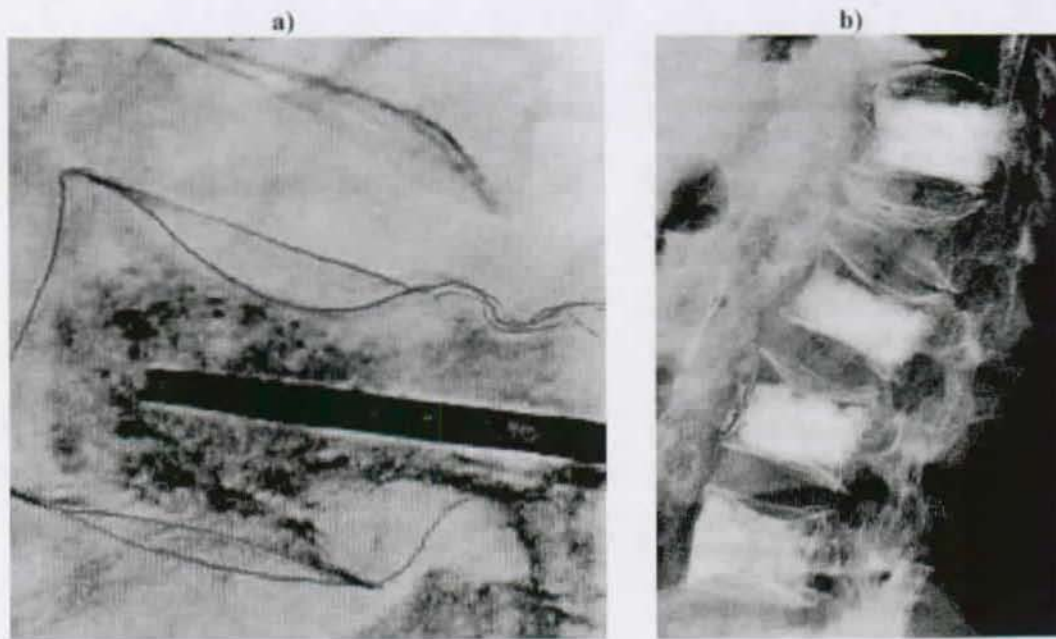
a) X-ray lateral view of a posterolateral transpedicular injection. b) Injected osteoporotic fractured vertebrae.
